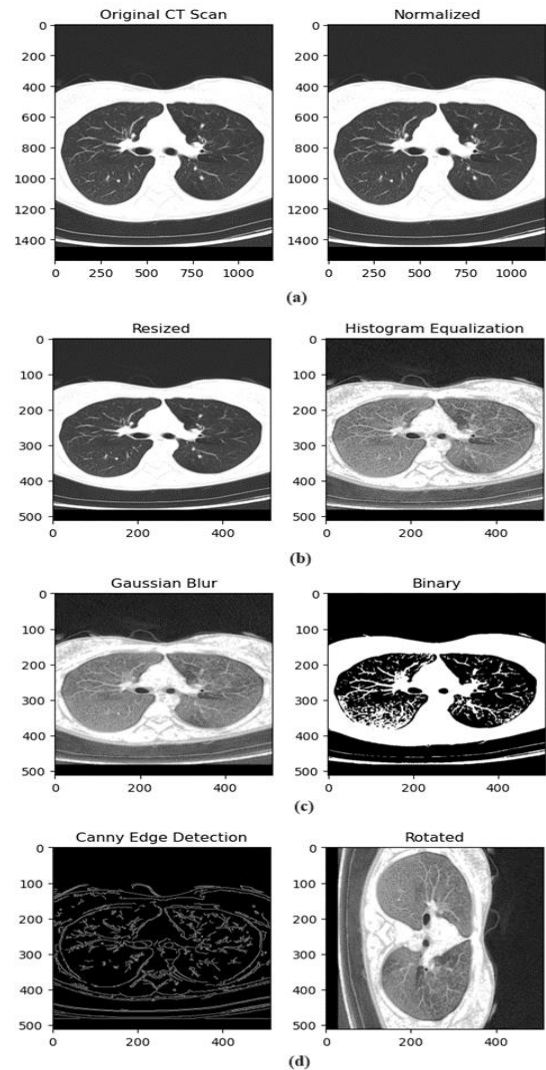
Preprocessing techniques applied to CT Scan Image
